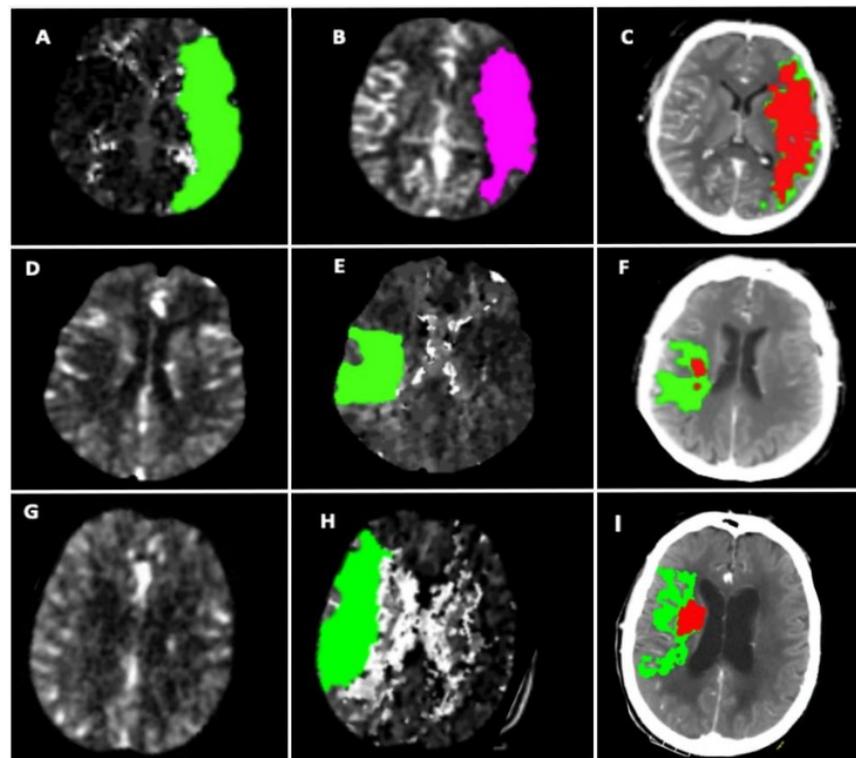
CT perfusion software comparison; for RAPID [Core (purple), Penumbra (green)] and AutoMISTar [Core (red), Penumbra (green)]. Patient 1 (A-C): Left M1 occlusion in a 35 year old male; RAPID: Core = 179 mL (A), Penumbra = 221 mL (B); AutoMISTar: Core = 98 mL, Penumbra = 160 mL (C). Patient 2 (D-F): Right M2 occlusion in a 45 year old male; RAPID:
